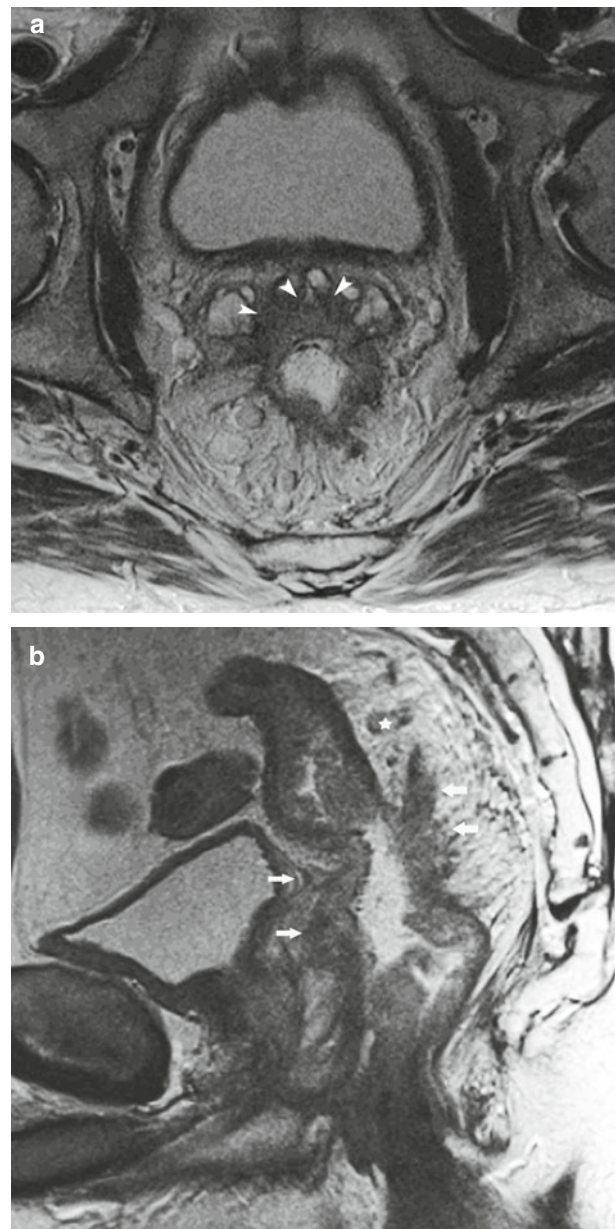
Axial T2-weighted image (a) showing a stage T4 tumor with invasion of the seminal vesicles (arrowheads). In the sagittal plane (b) infiltration of the seminal vesicles and prostate as well as extensive speculated invasion of the dorsal mesorectal fat can be recognized (arrows). Enlarged mesorectal lymph node (asterisk)
